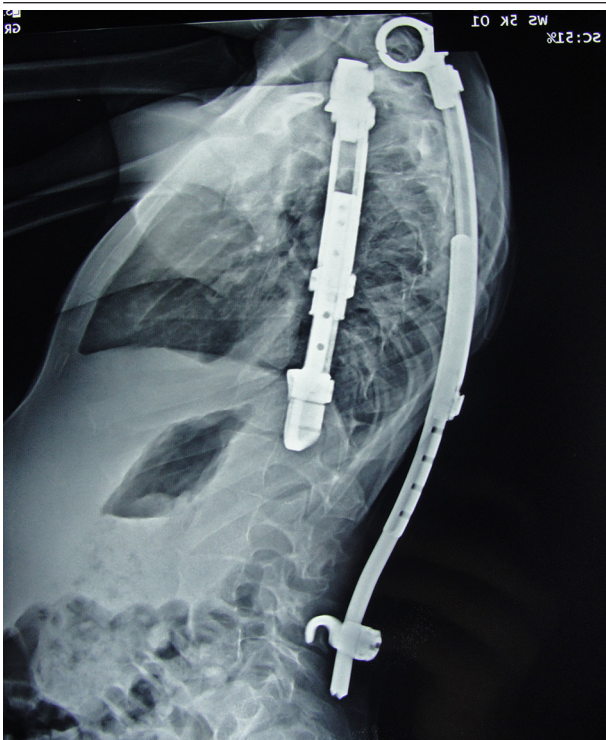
Lateral Radiograph of a 7-Year-Old Spondylocostal Dysplasia Boy Patient With a Rib to Rib and Rib to Spine VEPTR
